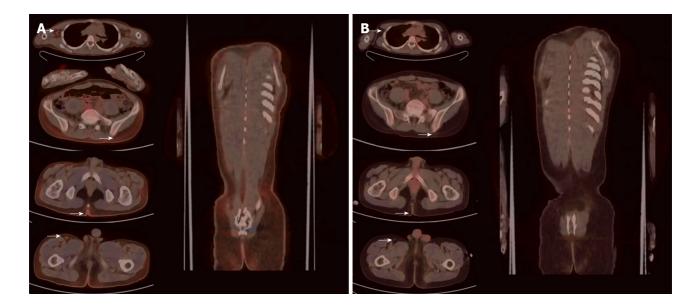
The patient underwent positron emission tomography/computed tomography before treatment and reexamination after 4 cycles of treatment. A: Positron emission tomography/computed tomography (PET/CT) before treatment. The figure showed mild systemic skin swelling and diffuse mild increase in glucose metabolism, especially in the local skin of both armpits, right upper quadrant, and posterior coccyx. Multiple small lymph nodes of different sizes with increased glucose metabolism were observed in both armpits and groins; B: PET/CT after treatment. The figure showed no clear structural or glucose metabolism abnormalities.
